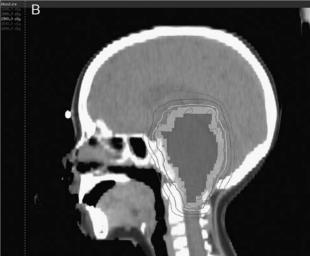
Sagittal image of computed tomography scan-based treatment plans for a 6-year-old girl with progressive brainstem glioma. A, Initial radiation treatment plan to 54 Gy; (B) reirradiation treatment plan to 20 Gy. The retreatment volume included nearly all of the previously irradiated area in this and in all other patients.
